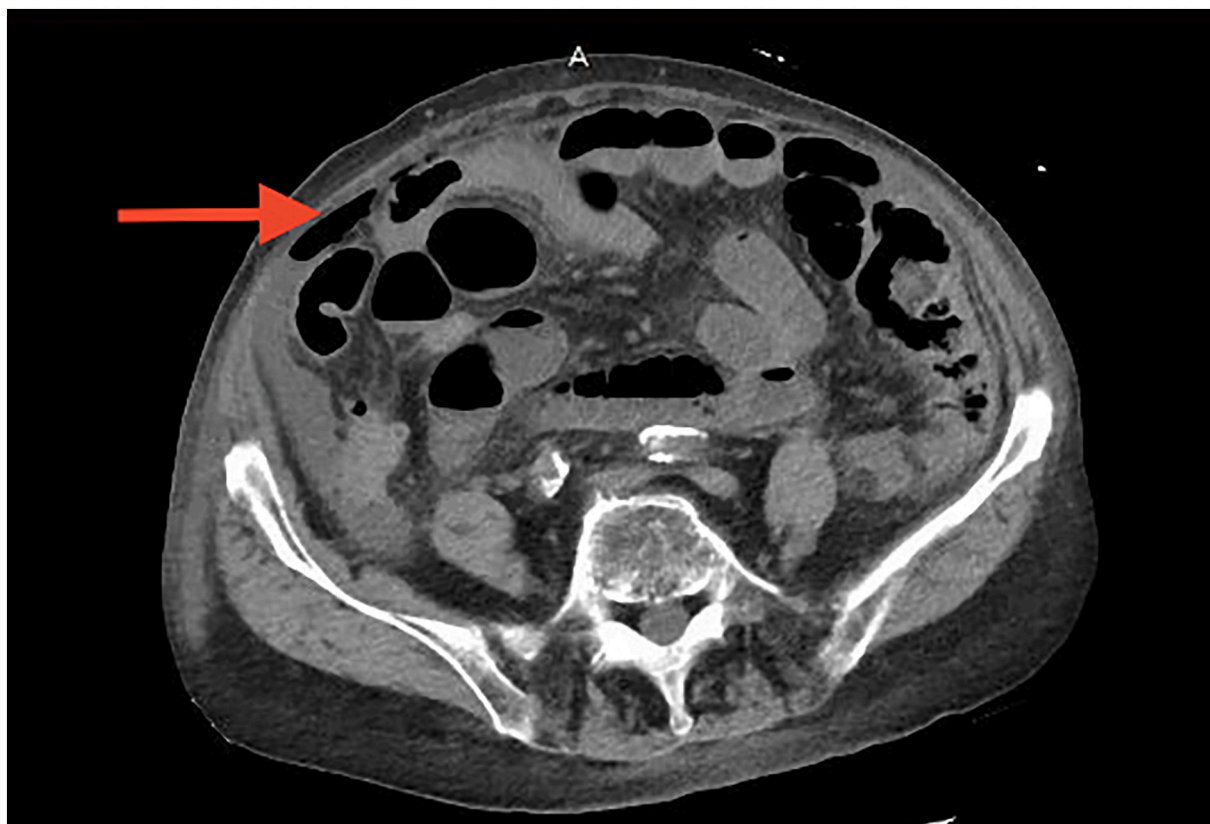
Computed tomography (CT) scan of the abdomen and pelvis, axial view Arrow pointing to free air (pneumoperitoneum).
